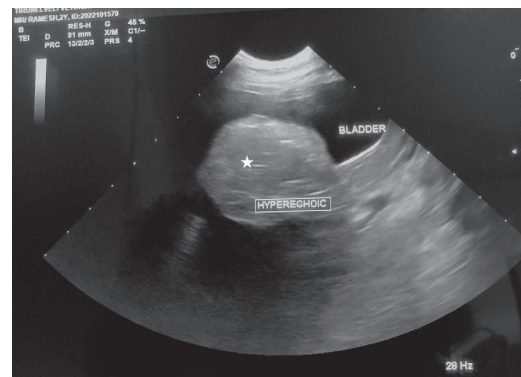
Sagittal plane ultrasound imaging of abdomen showing hyper echoic nodular mass in the peritoneal cavity
